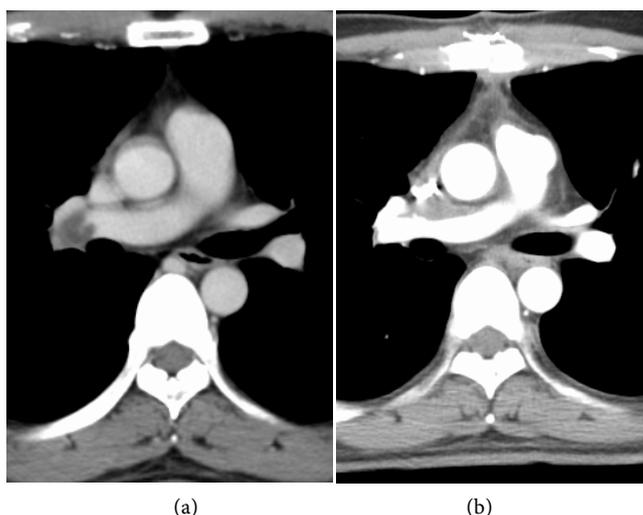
(a) Preoperative computed tomography scan showing tumor embolism in the right pulmonary artery (white arrow head); (b) Postoperative computed tomography scan showing no pulmonary tumor emboli.
